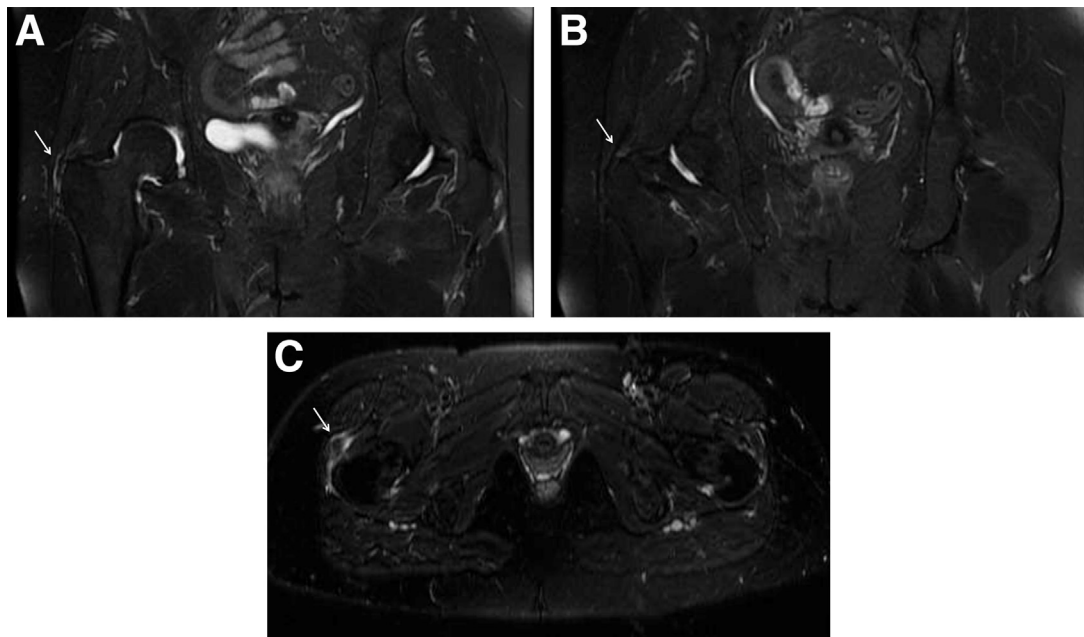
(A) Isolated partial-thickness gluteus medius tear. T2-weighted coronal series showing high signal at the insertion of the right gluteus medius tendon (arrow) at the level of the lateral footprint. (B) Isolated partial-thickness gluteus medius tear. T2-weighted coronal series of the right gluteus medius tendon showing that it does not extend to the superoposterior footprint (arrow). (C) Isolated partial-thickness gluteus minimus tear. T2-weighted axial series showing high signal at the insertion of the gluteus minimus (arrow) without involvement of the gluteus medius.
